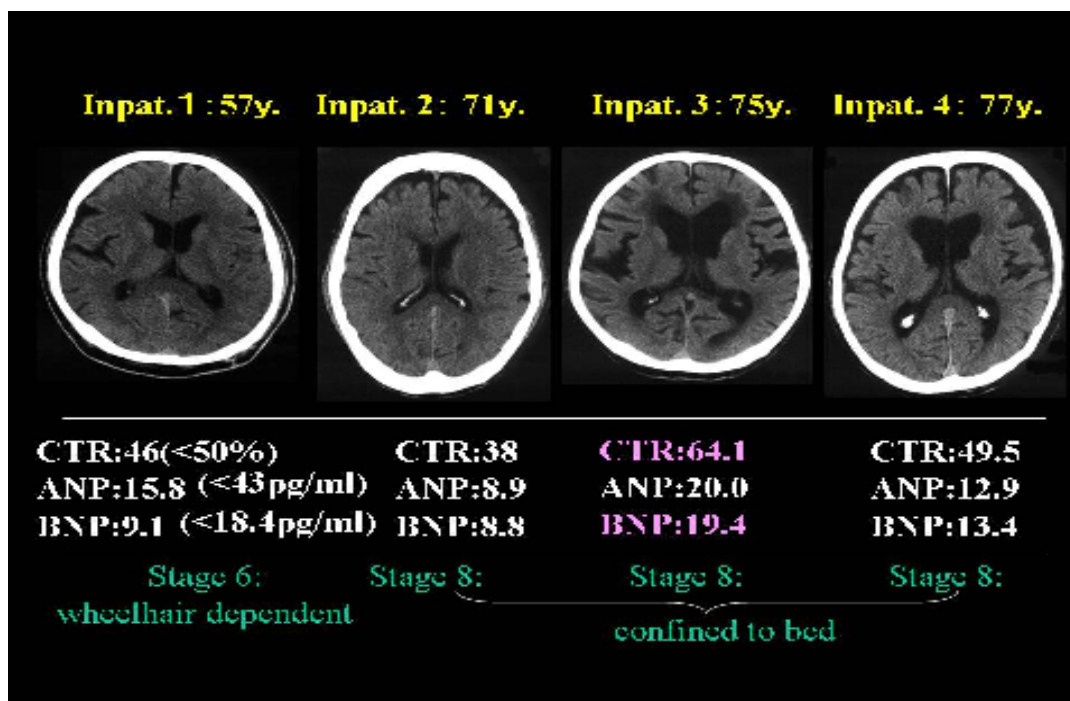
CT findings. We observed no association between the CT findings and the muscle function test.
